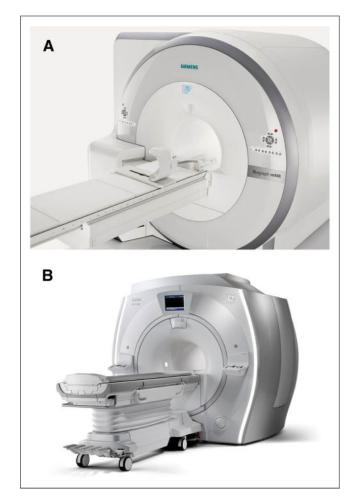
Integrated PET/MRI systems: Biograph mMR (Siemens) (A) and Signa PET/MR (GE Healthcare) (B). Both allow for simultaneous PET and MRI data acquisitions at 3-T field strengths. (Courtesy of Siemens and GE Healthcare.)
